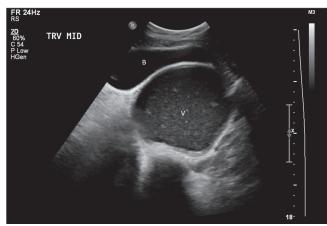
Ultrasound of the lower mid abdomen (transverse plane) demonstrating abnormality. B Bladder; V Vagina
